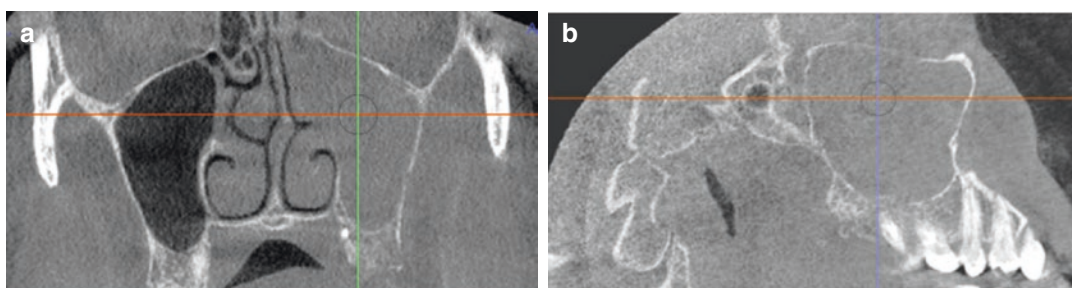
Axial (a) and sagittal (b) CBCT images of a 60-year-old female who presented for a dental implant in the mandibular left molar region. The images demonstrate a large, well-defined radiolucency in association with a retained root fragment of the maxillary right first premolar. The entity encroaches the maxillary sinus with a well-corticated border. The imaging appearance is consistent with a radicular cyst
